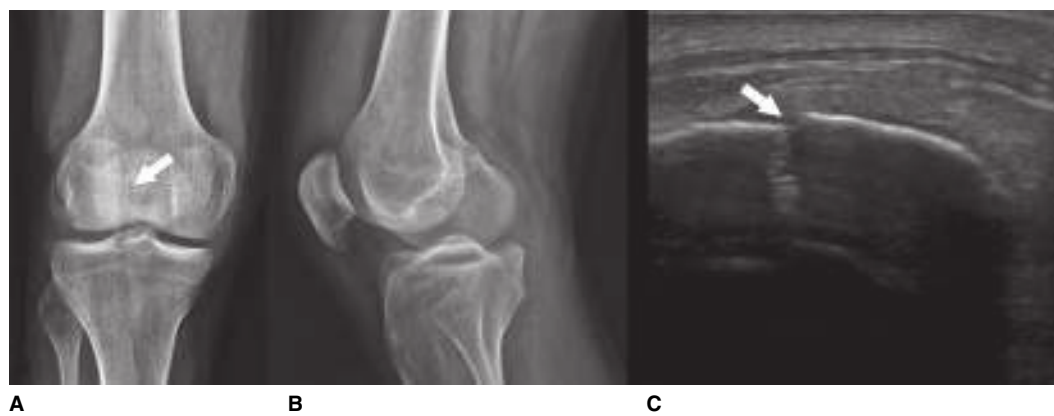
A patella fracture. A. Anteroposterior radiograph. B. Lateral radiograph. C. Longitudinal US view with the *arrow* pointing toward the fracture. (Used with permission from reference 35.)
